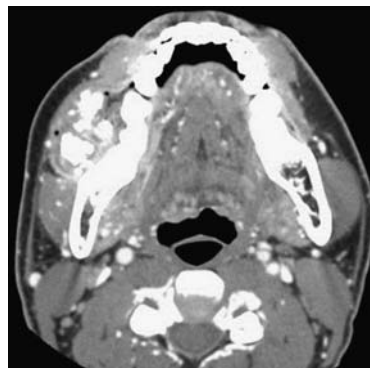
Computed tomography scan axial view shows a mass with numerous radiolucency masses in contact with third-molar socket, infiltrating soft tissues, and first and second molars (24 × 10-mm volume).
